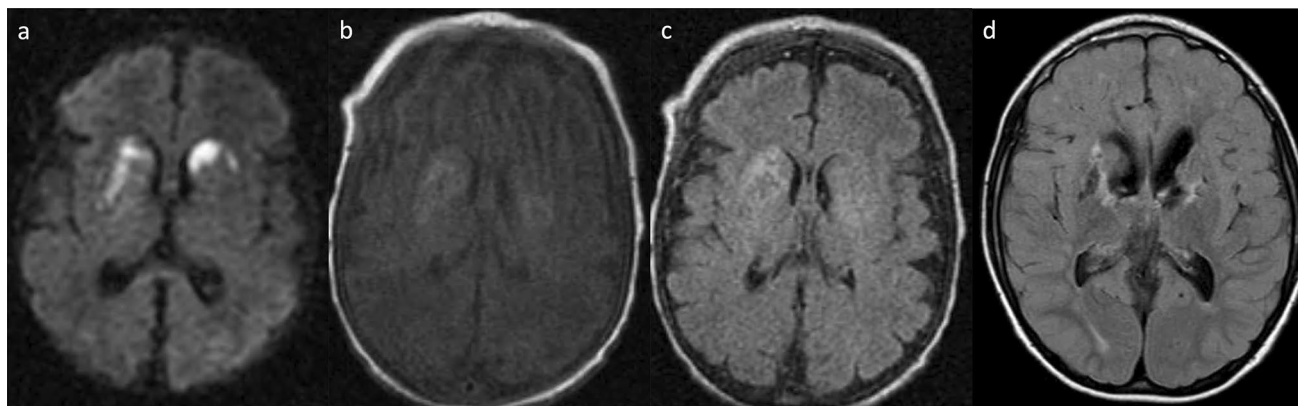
Cystathionine β -synthase deficiency (CBSD) and methylmalonic acidemia in a male neonate with seizure. Axial DWI (a) revealed hyperintense lesions in the bilateral caudate nuclei and putamina. Axial T1-weighted imaging (b) and FLAIR (c) imaging demonstrated mild swelling and hyperintensity in the right caudate
